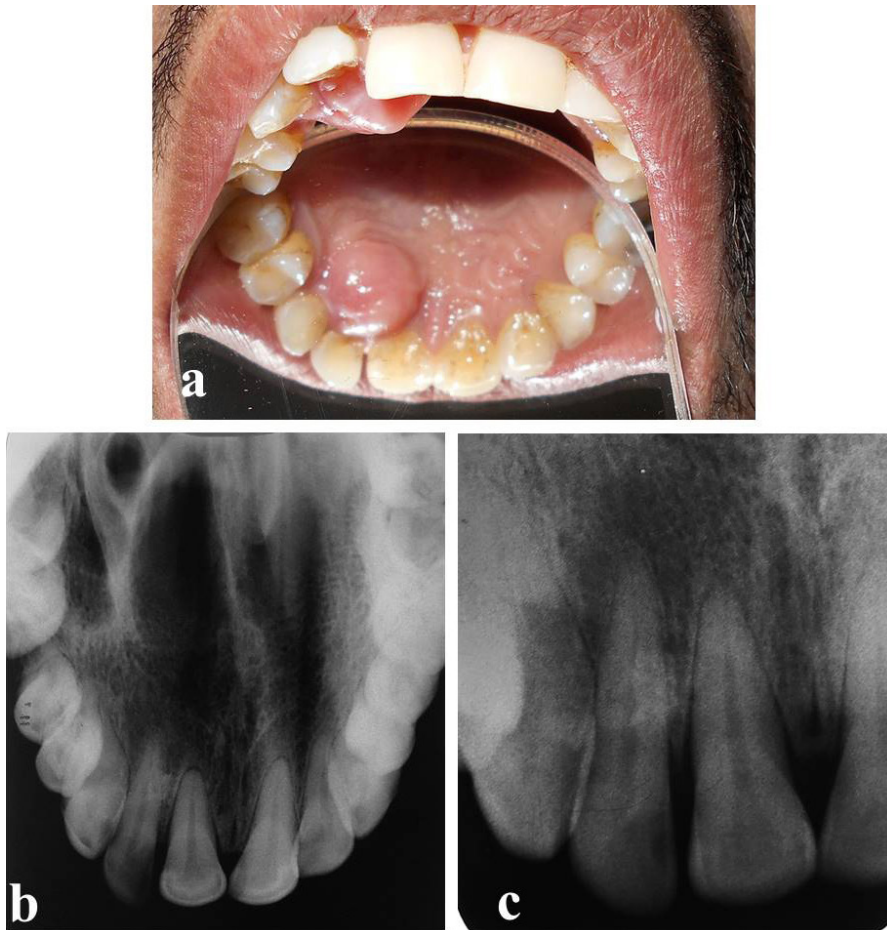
a) Pre-operative clinical picture of the sessile swelling over the palatal aspect of #11-13. b) Pre-operative Maxillary occlusal radiograph showing well defined radiopacity with irregular margins, in relation to the middle third region of #12 with distinct root outline and periodontal ligament space. c) Pre-operative intraoral periapical radiograph showing the same radiopacity in relation to root of #12.
